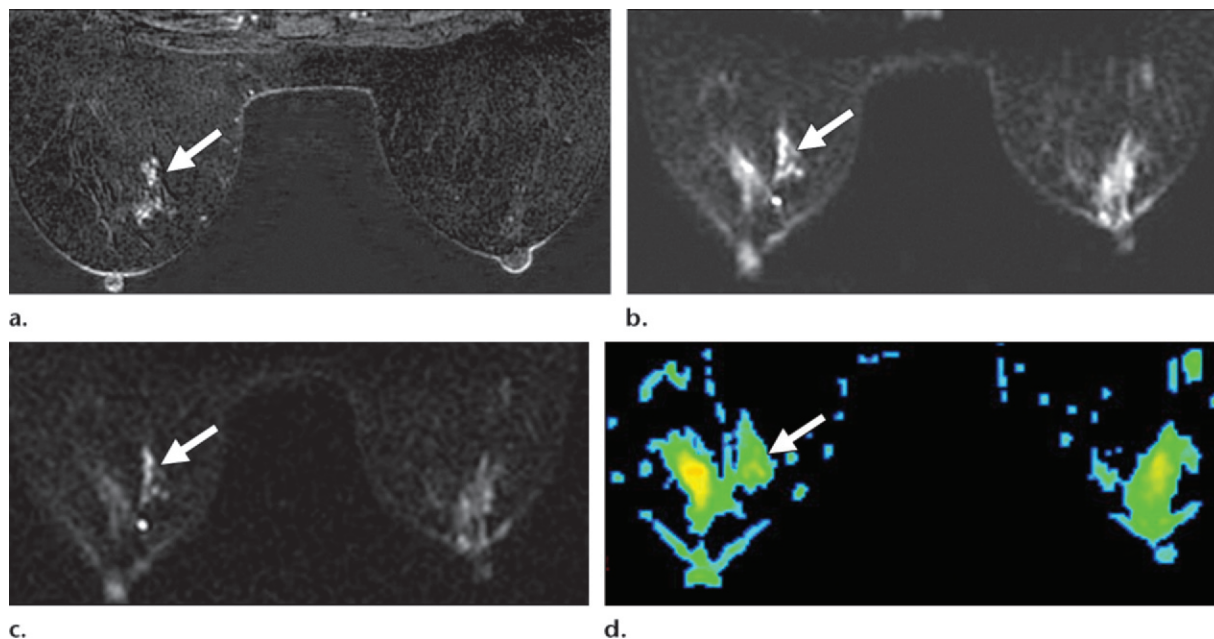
DCIS in the left breast. (a) Contrast-enhanced T1-weighted MR image (VIBRANT, TR/TE = 6.5/3.1, flip angle = 12°, bandwidth = ± 41.7 kHz, FOV = 360 mm, matrix = 360×360 , section thickness = 0.9 mm, no intersection gap, SpecIR with ASSET) shows segmental enhancement in the left breast (arrow), a finding that is compatible with DCIS. (b) On a diffusion-weighted image obtained at $b = 1000$ sec/mm² (spin-echo echoplanar imaging, TR/TE = 9800/77.6, bandwidth = ± 250 kHz, FOV aspect ratio = 0.8 [340×272], matrix = 160×192 , section thickness = 5 mm, no intersection gap, SSRF prepulse without ASSET), the signal intensities of the DCIS (arrow) and normal breast parenchyma are almost equivalent. (c) On a diffusion-weighted image obtained at $b = 1500$ sec/mm² (TR/TE = 9800/85.3), the difference between the signal intensity of the DCIS (arrow) and that of normal breast parenchyma is more evident than in b. (d) On an ADC map obtained at $b = 1500$ sec/mm², the difference between the color of the DCIS (arrow) and that of the surrounding normal breast parenchyma is quite subtle. The ADC value of the DCIS is 1.12×10^{-3} mm²/sec, and that of normal breast parenchyma is 1.48×10^{-3} mm²/sec.
